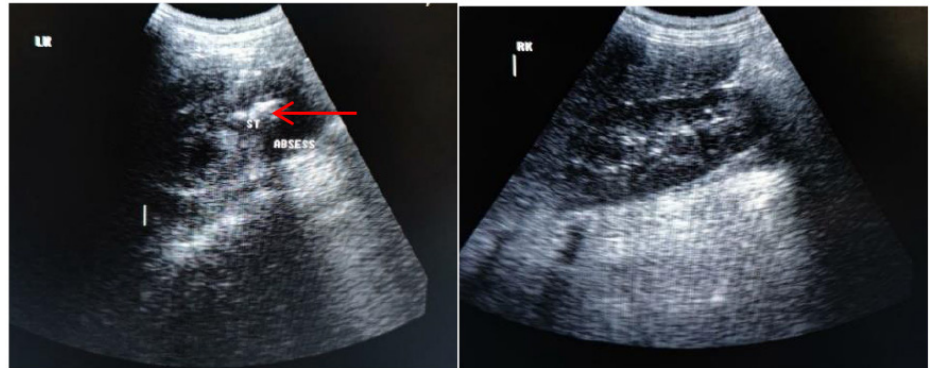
Ultrasound examination showed hyperechoic with acoustic shadow (red arrow) on left renal suspected as renal calculi with perirenal abscess
